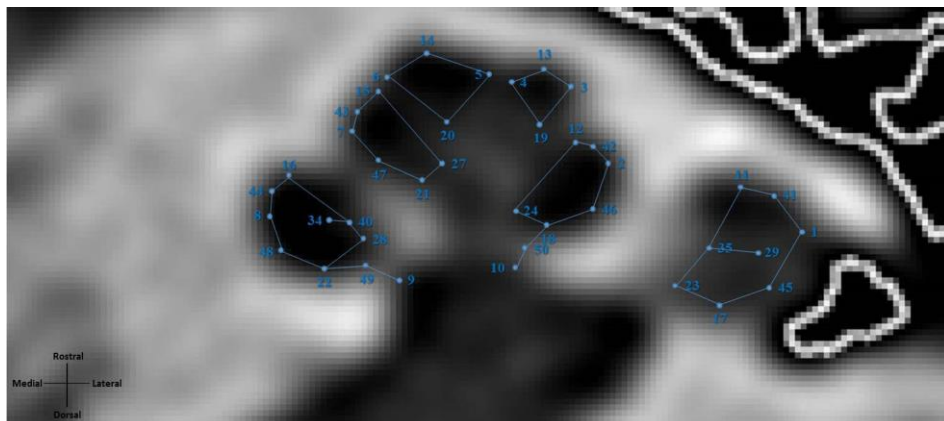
The identification and placement of the landmarks are shown on a μ CT scan. Landmarks that were not visible on the scan were placed outside the frame of the scan.
